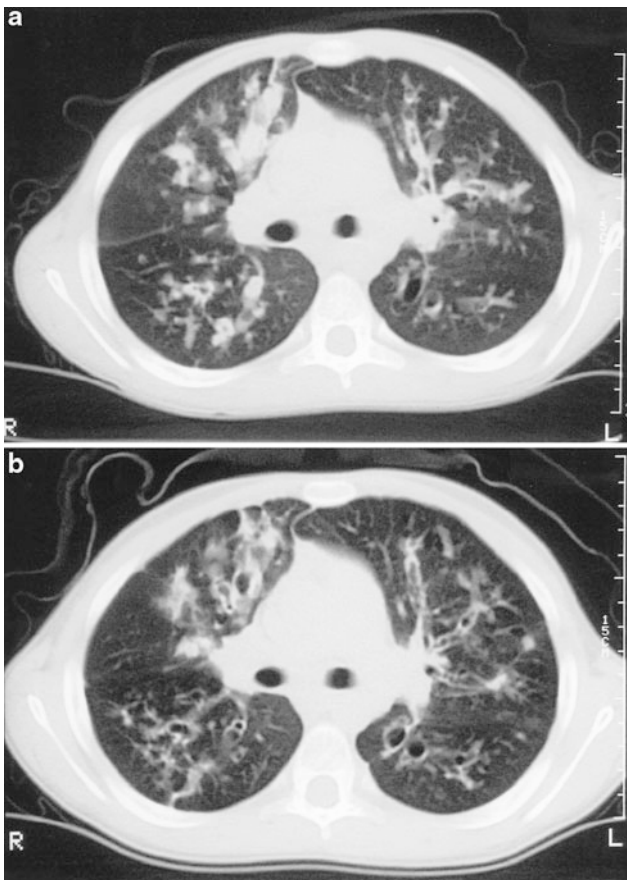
Cystic fibrosis (CF). An axial chest CT image (a) from an 11-year-old boy with CF shows bronchiectasis, bronchial wall thickening, and multiple sites of endobronchial mucous plugging. An axial chest CT image (b) obtained after several months of daily therapy with human recombinant DNase shows clearing of mucous plugs from many of the ectatic bronchi
